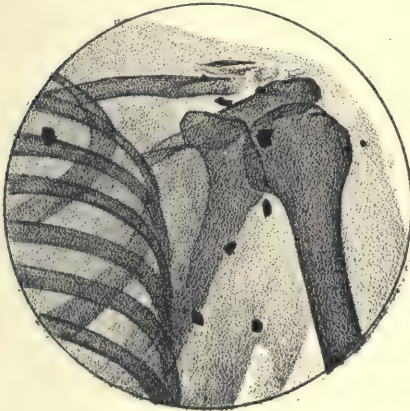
Radiograph of the right shoulder seen from its posterior aspect. (It will be noted that the external extremity of the clavicle has been fractured and some parts are missing.) Eight metal fragments of rather a large size can be counted in the region of the shoulder. The wound was caused by a shell.
